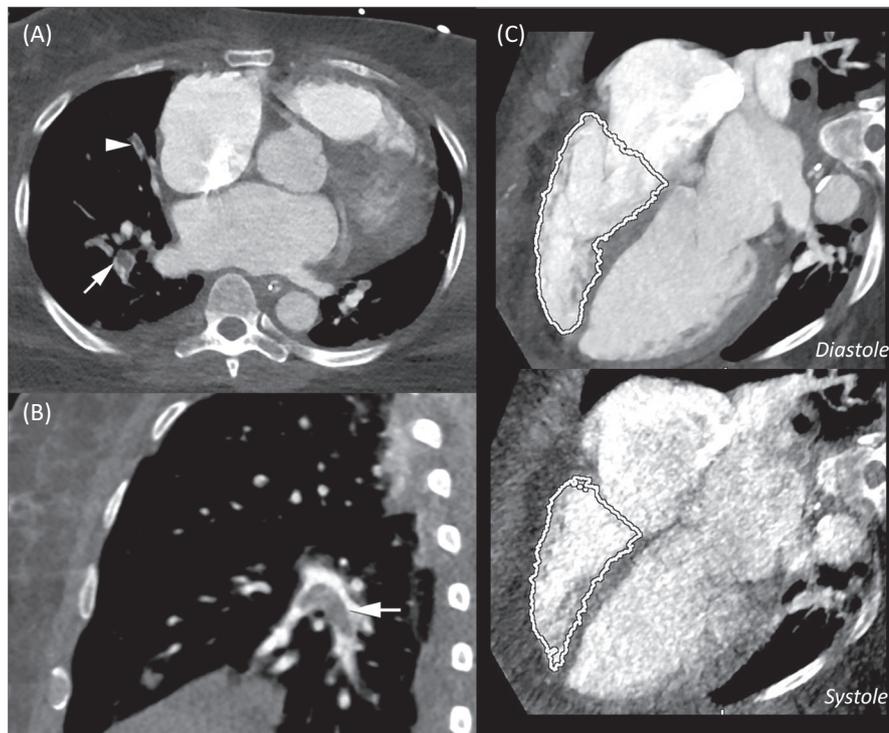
(A) SDCT following resuscitation of a 49-year-old woman with known idiopathic cardiomyopathy (left ventricular ejection fraction of 25%) found down with asystole. Pulmonary emboli in right middle (arrowhead) and lower (arrow) lobe pulmonary arteries in axial (A) and sagittal (B) CT images. (C) Severely enlarged right ventricle (end diastolic volume indexed for body mass index at 140 mL/m² mL) with mildly reduced systolic function with a 3D ejection fraction of 53%. Severely enlarged left ventricle (end diastolic volume index 138 mL/m² mL) with moderately reduced function and a 3D ejection fraction of 31%. Thrombolytics were deferred. Treated with IV heparin and transitioned to apixaban for lifelong therapy. SDCT, sudden-death computed tomography
